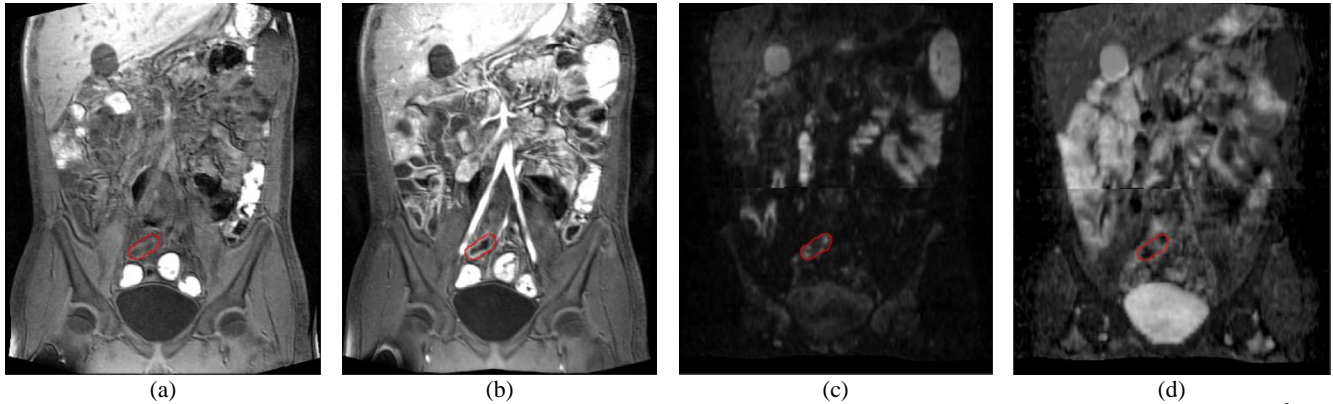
The whole-body T1w structural images (a) before and (b) after contrast injection along with (c) DW-MRI image ($b=800 \text{ s/mm}^2$) and (d) ADC map generated from the acquired DW-MR images from coronal and axial views. The manually segmented enhanced bowel wall has been circled in red in the images.
